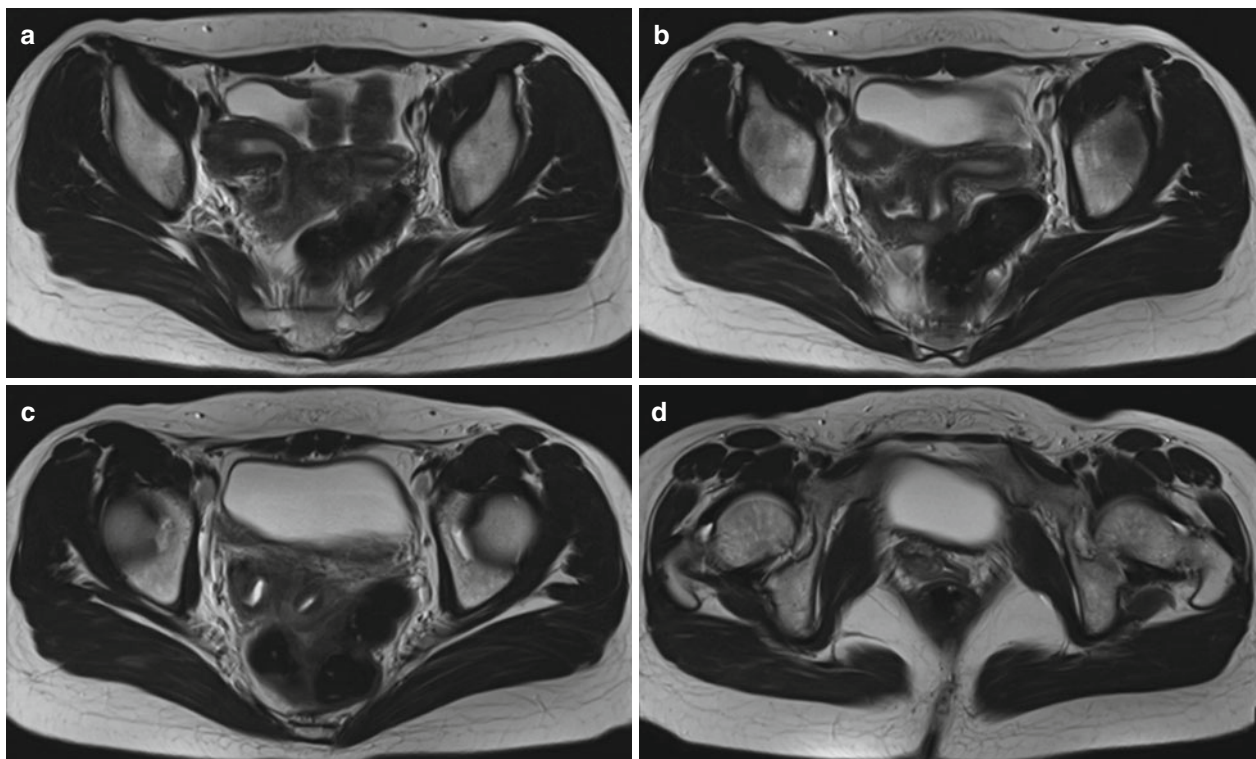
Uterine didelphys in a 15-year-old girl. T2-weighted axial MR images of pelvis show two uterine horns (a, b), two cervixes (c), two separate vaginal lumens (d)
